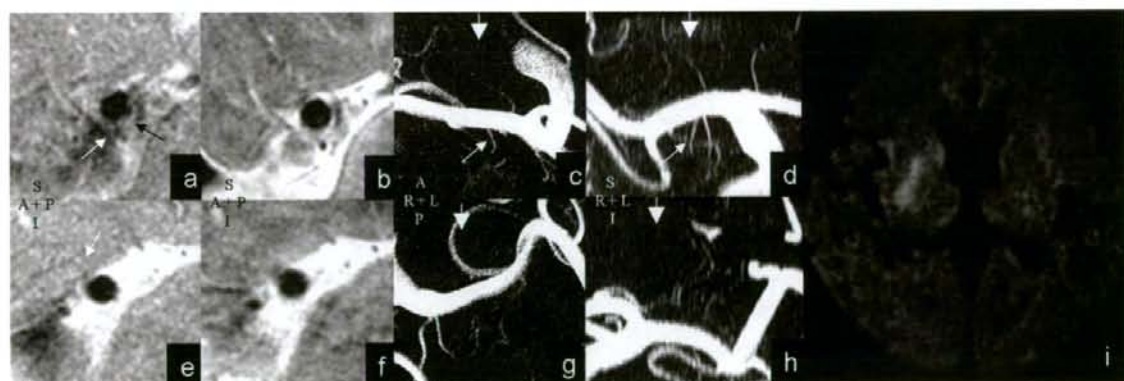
sagittal T<sub>1</sub>w(a,e), T<sub>2</sub>w(b,f), MRA (maximum intensity projected image through superior-inferior (c,g) and anterior-posterior (d,h) direction) images of possible MCA-M1 BAD patient at affected right side (a-d) and normal left side (e-h) and DWI(i). Black arrows show possible plaque, white arrows show perforators and white arrow heads show slice locations of T<sub>1</sub>w and T<sub>2</sub>w images.
